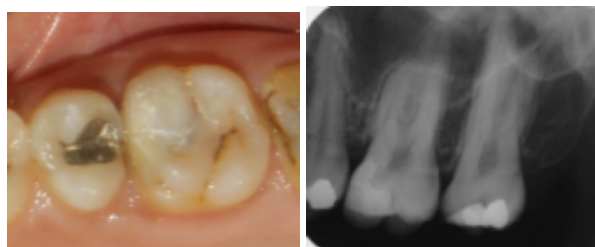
Postoperative intraoral and radiographic view
